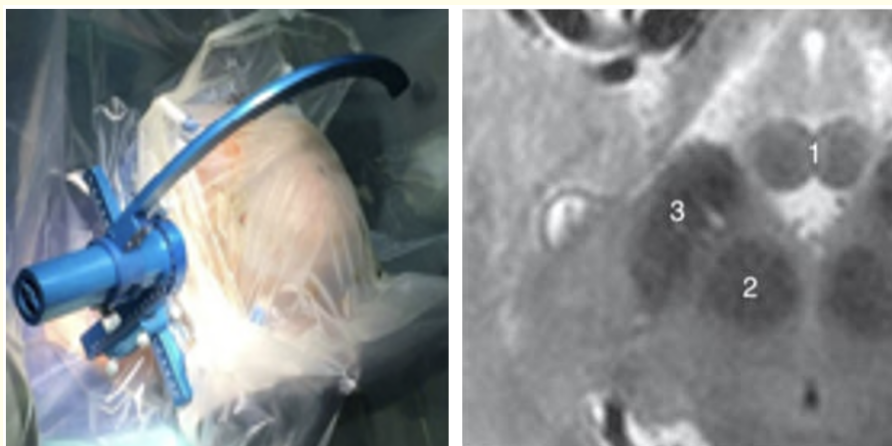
Stereotactic frame. Figure 20B: MRI 1. Mammillary tubercles, 2. N.R., 3. STN.
